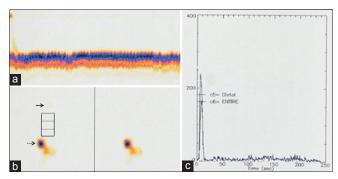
Esophageal transit scintigraphy done with liquid bolus in supine position in 29-year-old man showing condensed dynamic images (a), whole and segmental esophageal region of interest showing transit of liquid bolus (b) (solid arrow shows tracer activity in the mouth; broken arrow shows tracer activity in the proximal stomach), whole and segmental esophageal time activity curves (c)
